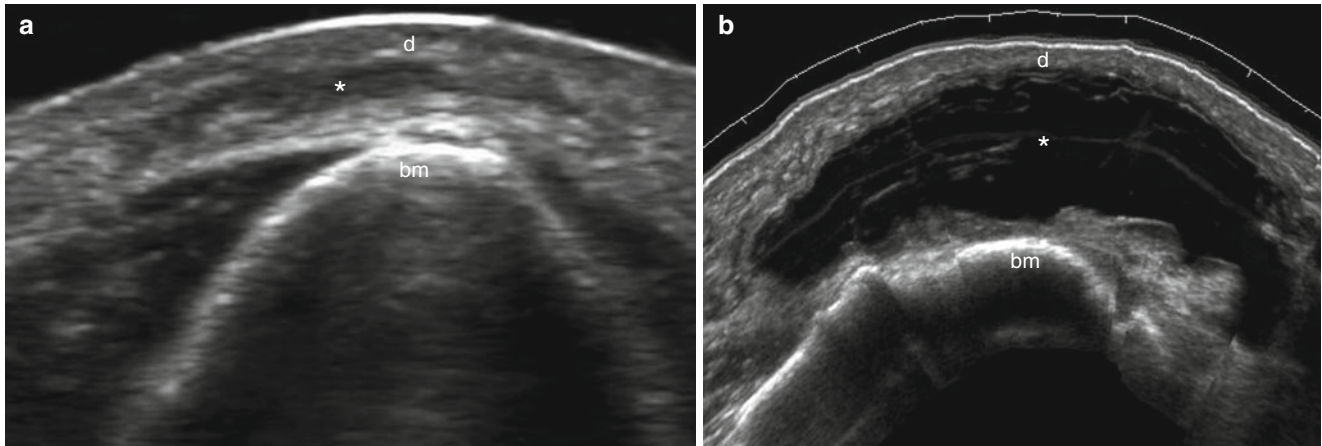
(a, b) Anatomy of bursae. (a) Ultrasound at the tip of the olecranon (transverse view). Note slight hypoechoic thickening of olecranon bursa capsule (*). Abbreviations: *d* dermis, *bm* bony margin of the olecranon
